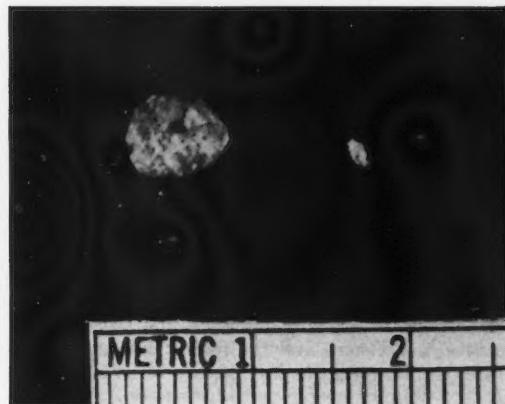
The two stones shown by x-ray in Figure 1. Note that the larger is almost 7 mm. in diameter. (Reproduced by permission of Gastroenterology.)
